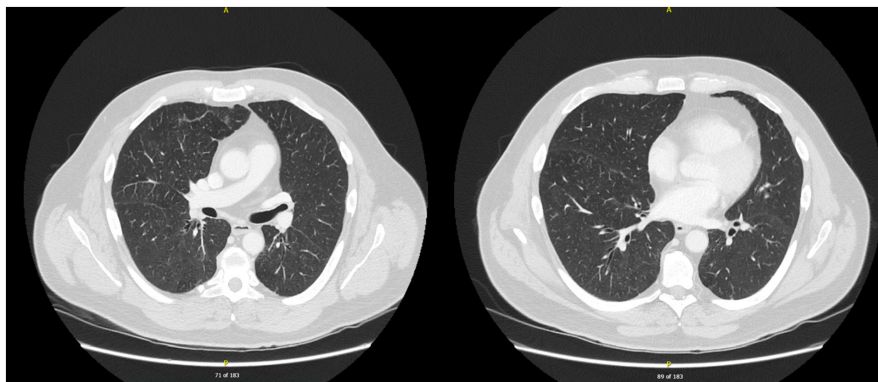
Resolution of the pulmonary abnormality on computed tomography (CT) of the chest 2 months later
